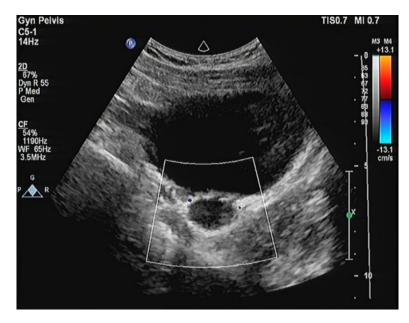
Ultrasound showed a cystic mass in the left adnexal area, with an irregular shape, a capsule that was full of thin and point-like echoes, and detectable blood flow signals at the cystic wall.
